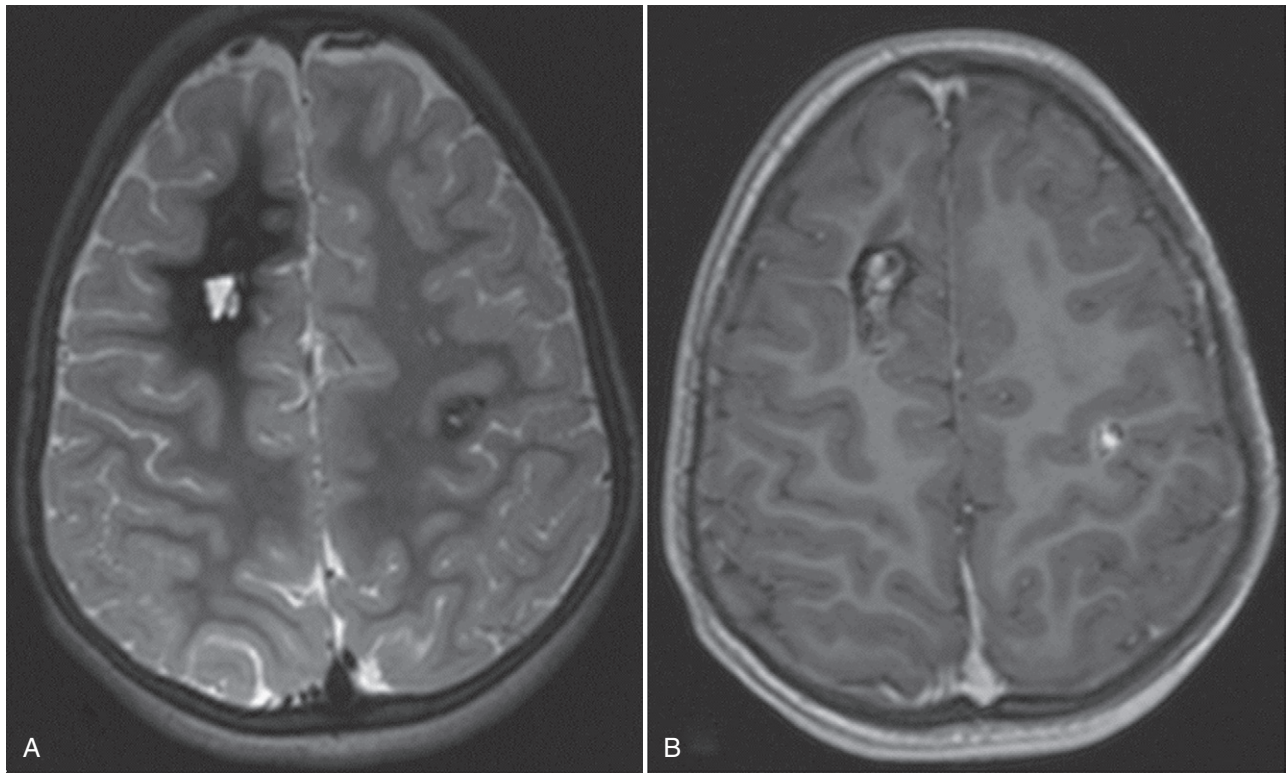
T2 (A) and T1 (B) MR images of a large right frontal cavernous hemangioma and an additional small cavernous hemangioma in the left perisylvian region.
